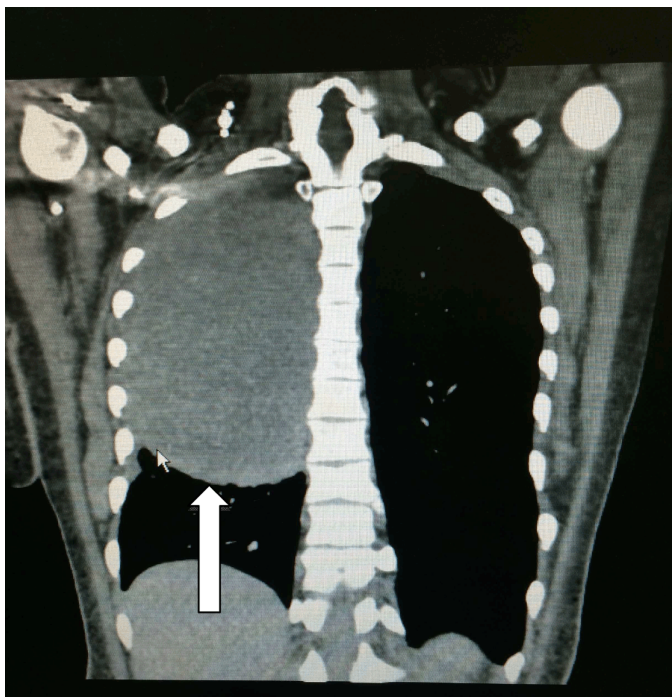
Computed tomography scan of chest with contrast revealing 12.4x15.4x16.5 cm necrotic right upper lung mass which nearly entirely replaces the right upper lobe.
